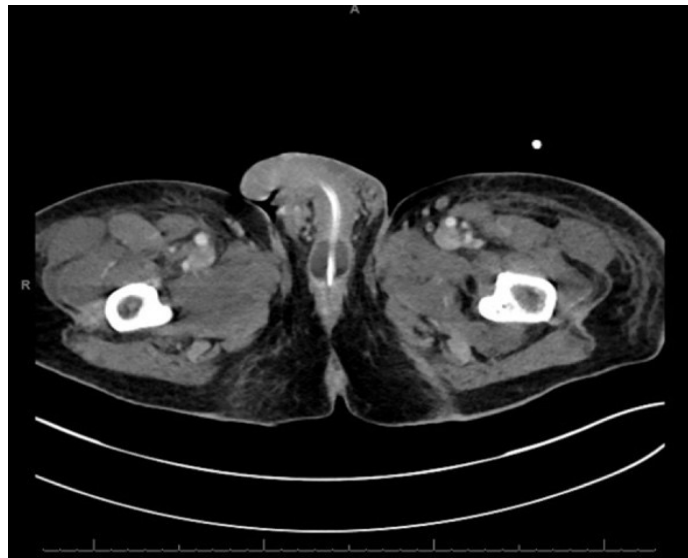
CT image demonstrating an inflated Foley catheter balloon within the penile urethra.
